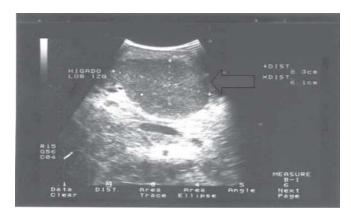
Abdominal sonogram showing another large hypoechoic mass in the left lobe.
